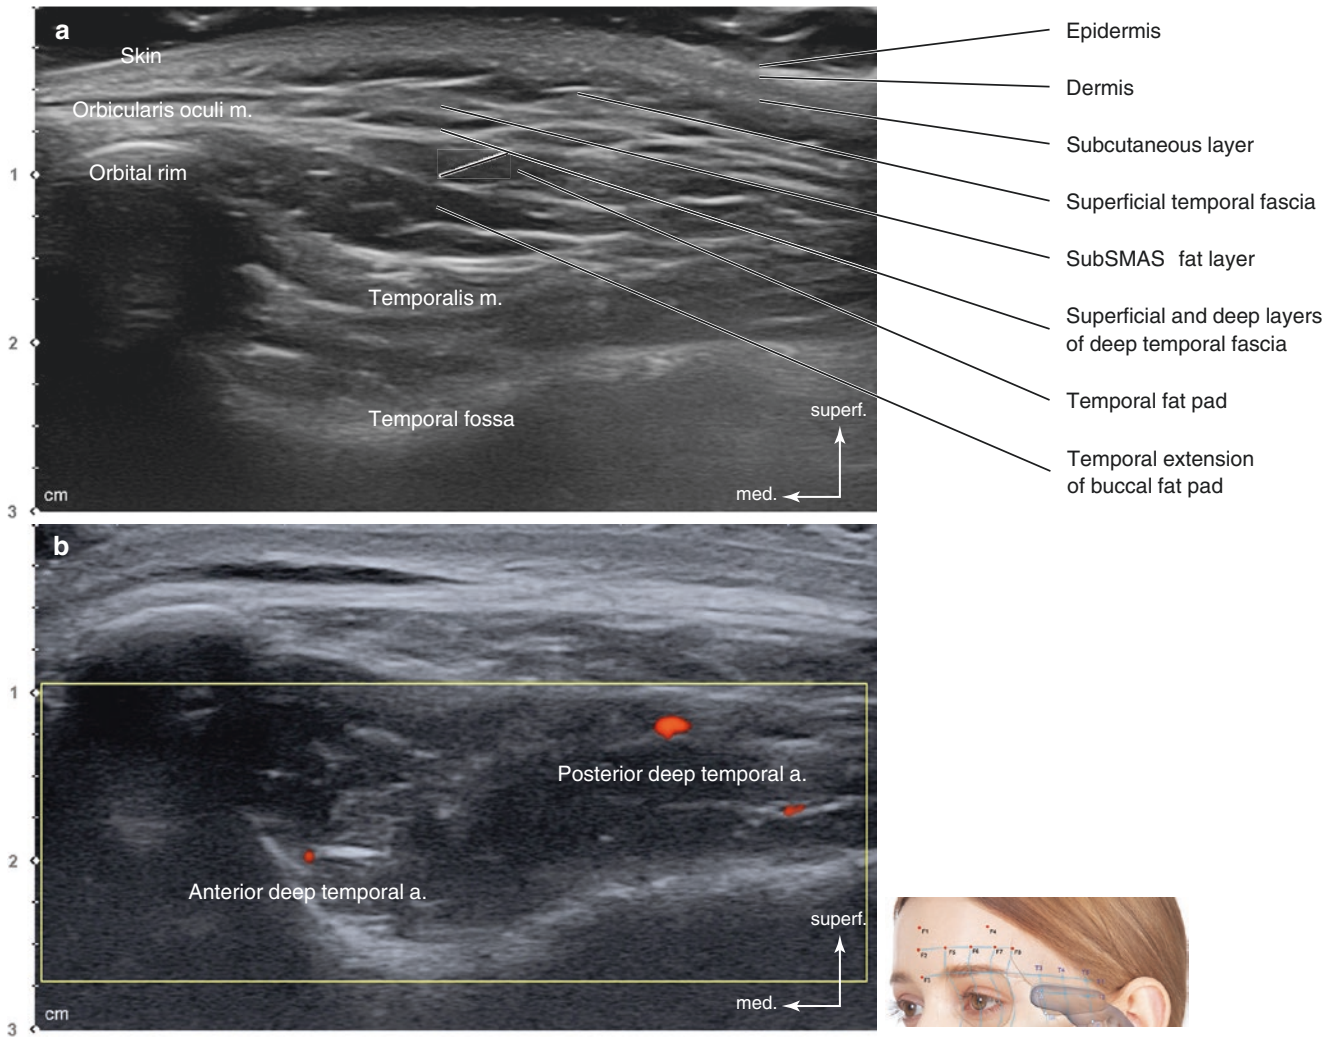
Ultrasonography of the transverse line passing the zygomatic tubercle (T2). (a) B mode (transverse view, 15 MHz by linear transducer) and (b) Doppler mode (transverse view, 15 MHz by linear
